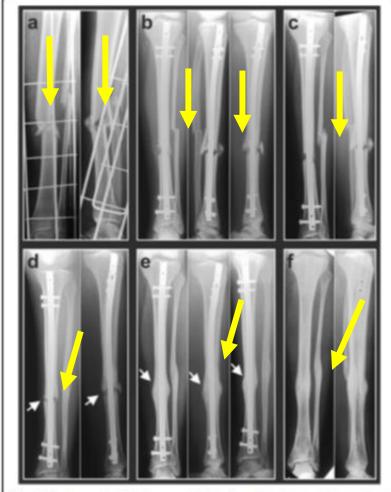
Radiographs of a 14-year-old-girl who suffered in a traffic accident a combined fracture of the left tibia and fibula, showing the situation immediately after the accident (a) as well as 2 weeks (b), 3 months (c), and 12 months (d) after the accident. Fracture consolidation was still not achieved (arrows in d), and the patient experienced severe pain during walking. At that time, a series of four rESWT sessions was started. Six months later (e), the patient was pain-free during walking, and radiographic consolidation was achieved (arrows in e). Another 12 months later, the intramedullary nail was removed (f)
